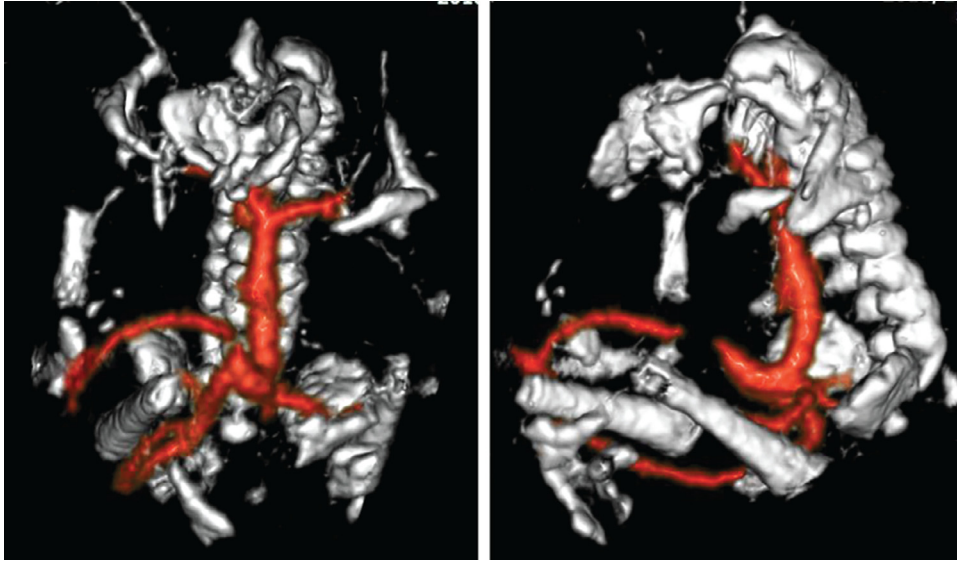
3D reconstruction image of enhanced-contrast CT Spinal column- and lower limb-like skeletal structures and vascular structures were observed. The vascular structures resembled the aorta, bilateral common iliac arteries and umbilical arteries branching therefrom.
